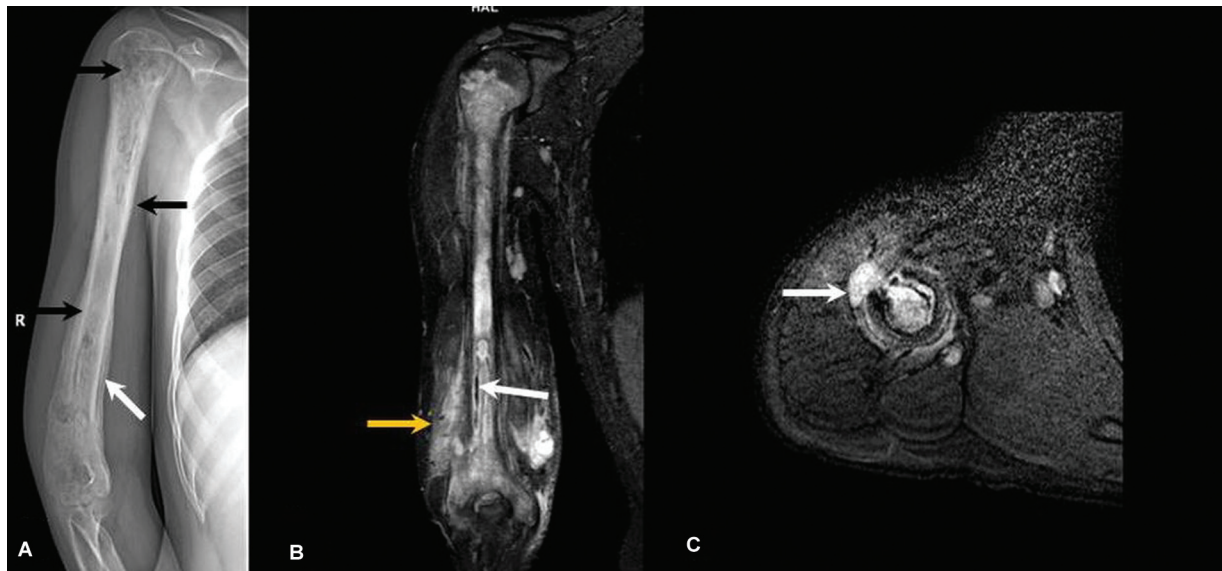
Differential diagnoses of chronic nonbacterial osteomyelitis (CNO): Chronic bacterial osteomyelitis. Frontal radiograph of the right humerus shows ill-defined permeative destruction (black arrows, A) of the almost the entire humeral shaft with associated lamellated periosteal reaction (white arrow, A). Coronal (B) and axial (C) short tau inversion recovery (STIR) images show diffusely altered marrow signal within humerus with T2 hypointense sequestrum formation in the lower aspect (white arrow, B), subperiosteal T2 hyperintense soft tissue (yellow arrow) and a defect in the anterior cortex, suggesting cloaca formation (arrow, C).
